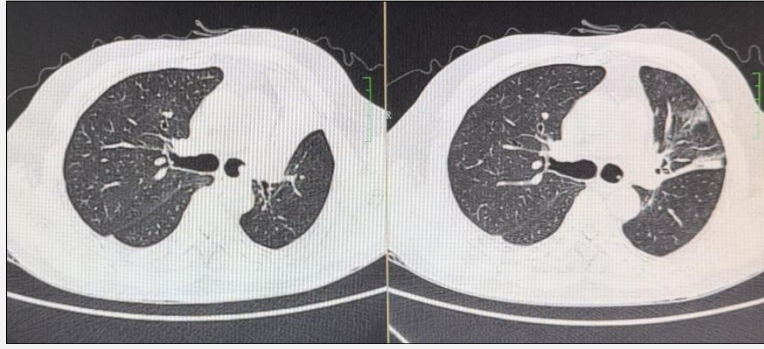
Chest CT changes.
